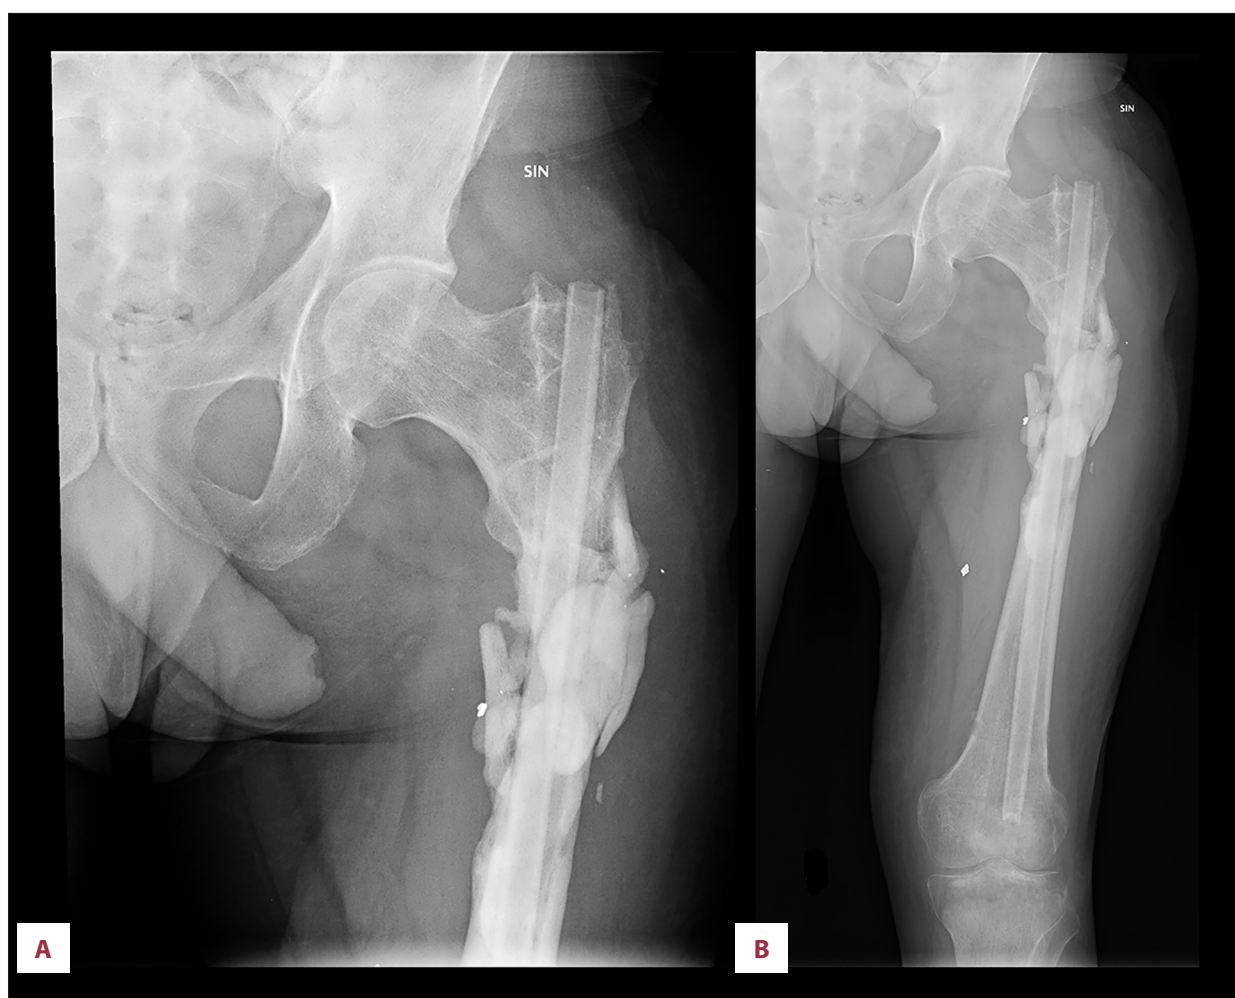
Reconstruction of the femoral defect using the Masquelet induced membrane technique. X-ray (anteroposterior [A, B]) showing the condition after a femoral defect caused by an explosion.
